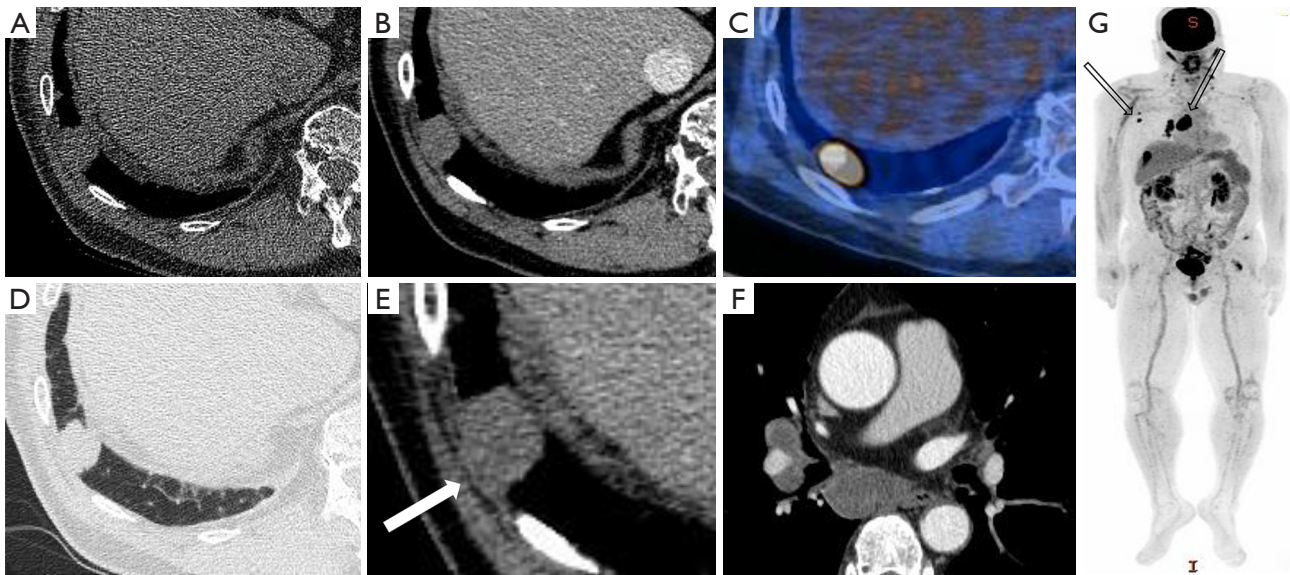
A 63-year-old man with SMARCA4-deficient non-small cell lung cancer. Unenhanced (A,D) and enhanced (B,E) CT scans show enhancing nodule with lobulated contour in right lower lobe periphery, and the nodule shows chest wall invasion (arrow). On enhanced CT (F), it shows multiple enlarged lymph nodes with necrotic changes in subcarinal and right interlobar areas. On MIP (G) and fusion image of PET-CT (C), the nodule shows diffuse intense FDG uptake ($SUV_{max} = 14.9$). On MIP (G) right axillary, right hilar and right mediastinal also show FDG uptake (open arrows), suggesting metastasis. CT, computed tomography; MIP, maximum-intensity-projection; PET, positron emission tomography; FDG, fluorodeoxyglucose; SUV_{max} , maximum standardized uptake value.
